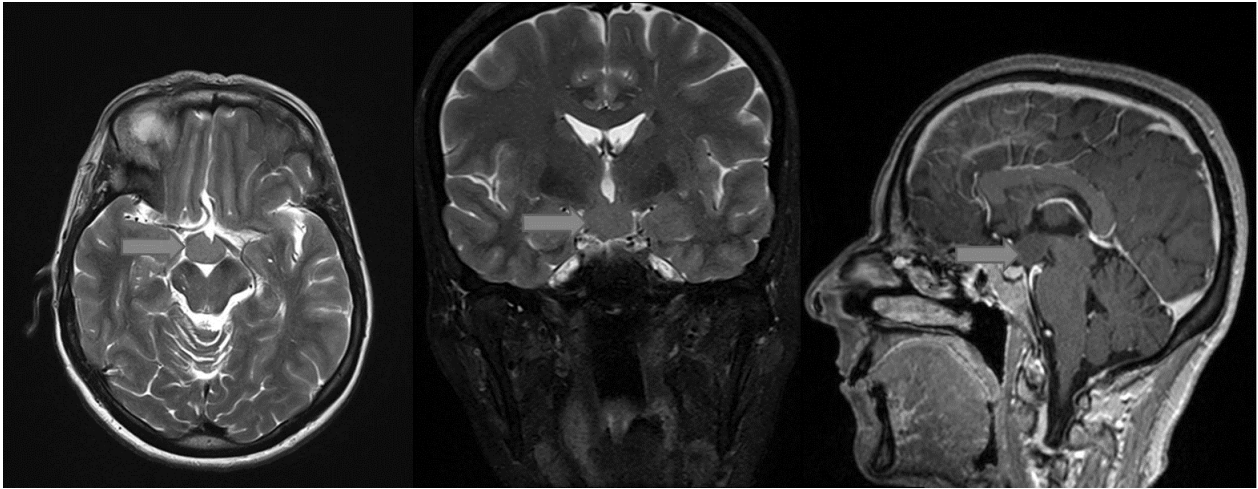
Brain MRI showing hypothalamic hamartoma in our patient
